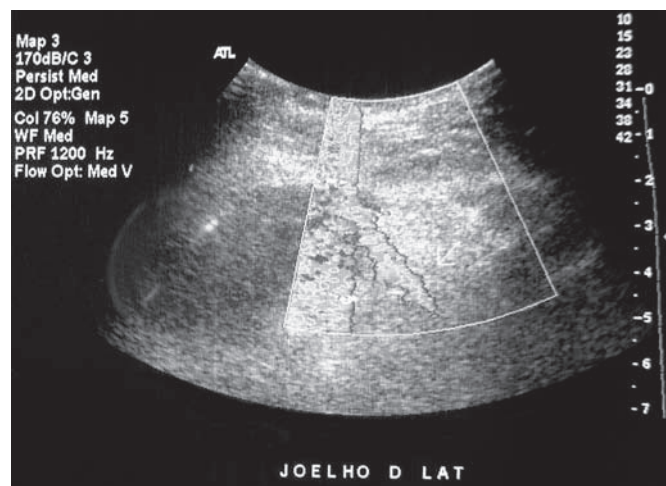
Arterial ultrasonography of right lower limb with the presence of pseudoaneurysm on the lateral side of the knee.
